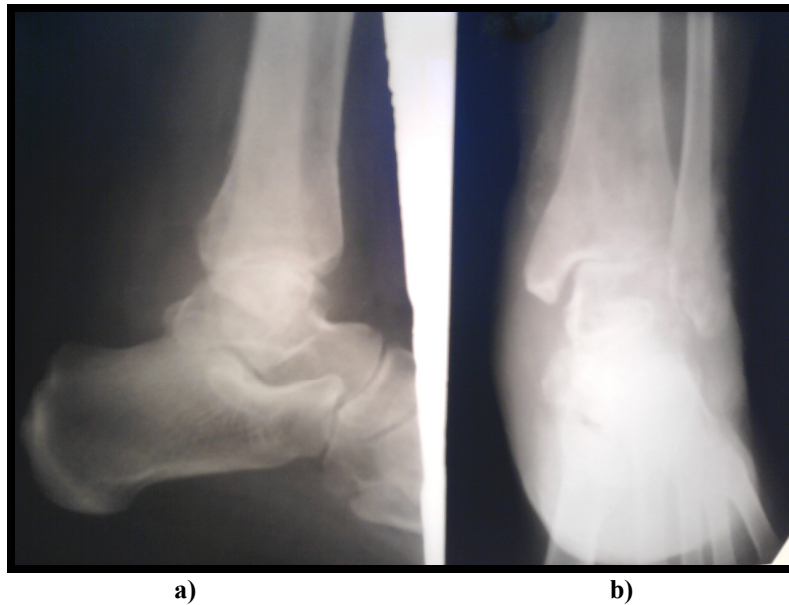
lateral (a) and anteroposterior (b) X-rays of the ankle showing subchondral cysts in the body of the talus and distal tibia with juxta-articular osteoporotic changes and joint space narrowing.
